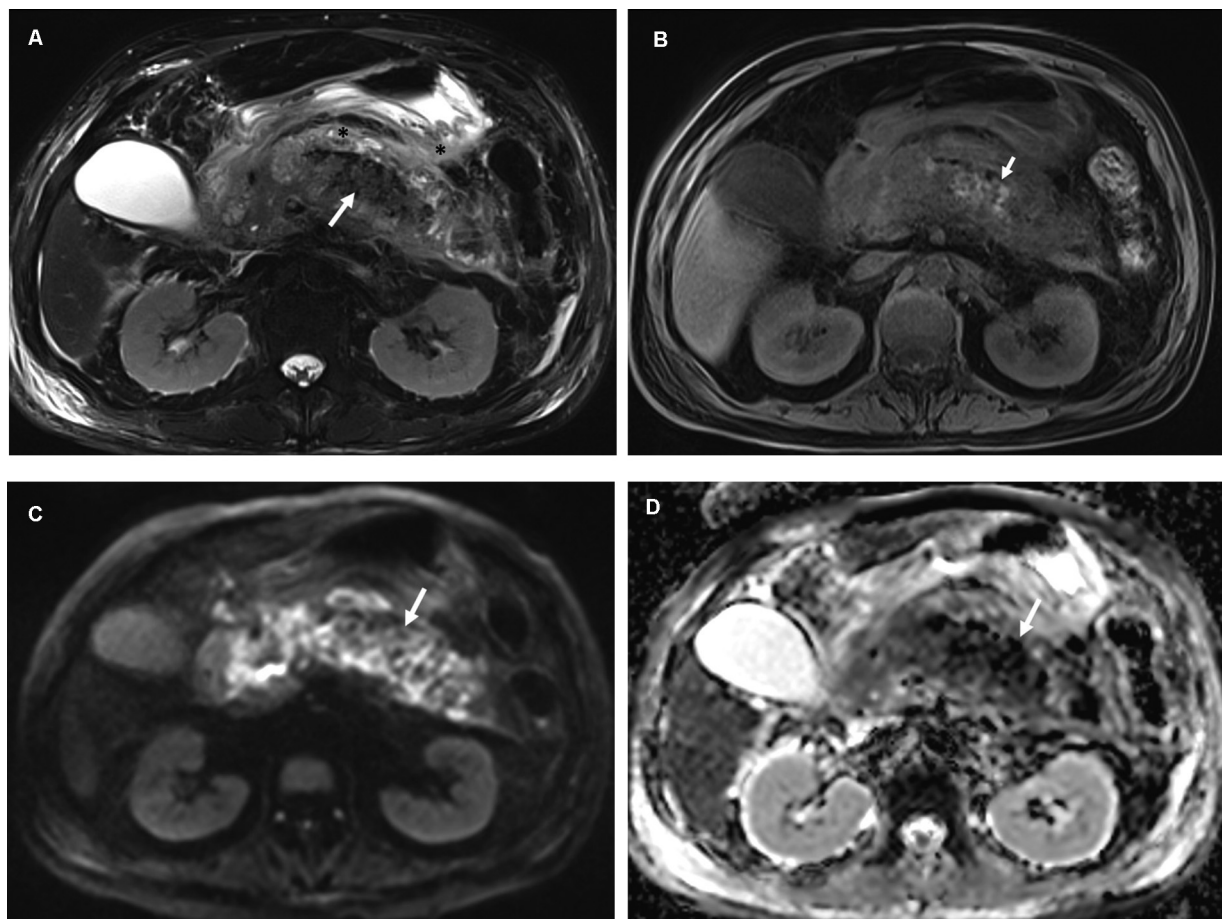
Magnetic resonance imaging (MRI) in a 50/M with acute alcohol-related necrotizing pancreatitis and hemorrhage. (A) T2-weighted (T2W) fat-suppressed (FS) in axial plane shows a bulky pancreas with hypointense areas in the body (white arrow). The black star represents peripancreatic fluid. (B) T1W FS in axial plane shows hyperintense areas (white arrow), corresponding to the hypointense areas in image A. (C) Diffusion-weighted imaging (DWI) in axial plane shows these areas to be heterogeneous (white arrow). (D) Apparent diffusion coefficient (ADC) in axial plane shows these areas are hypointense (white arrow).
